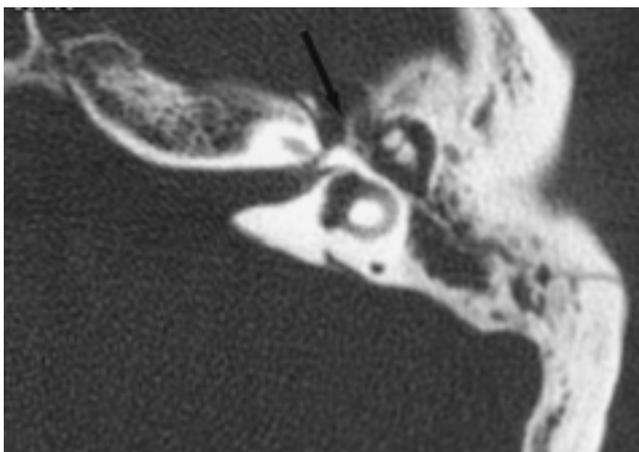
A 42-year-old man with grade II facial nerve palsy after temporal bone injury. Axial CT shows longitudinal fracture involving ganglionic segment of the facial nerve with discontinuity and displacement of bony wall of the facial nerve canal with canal widening(arrow).
